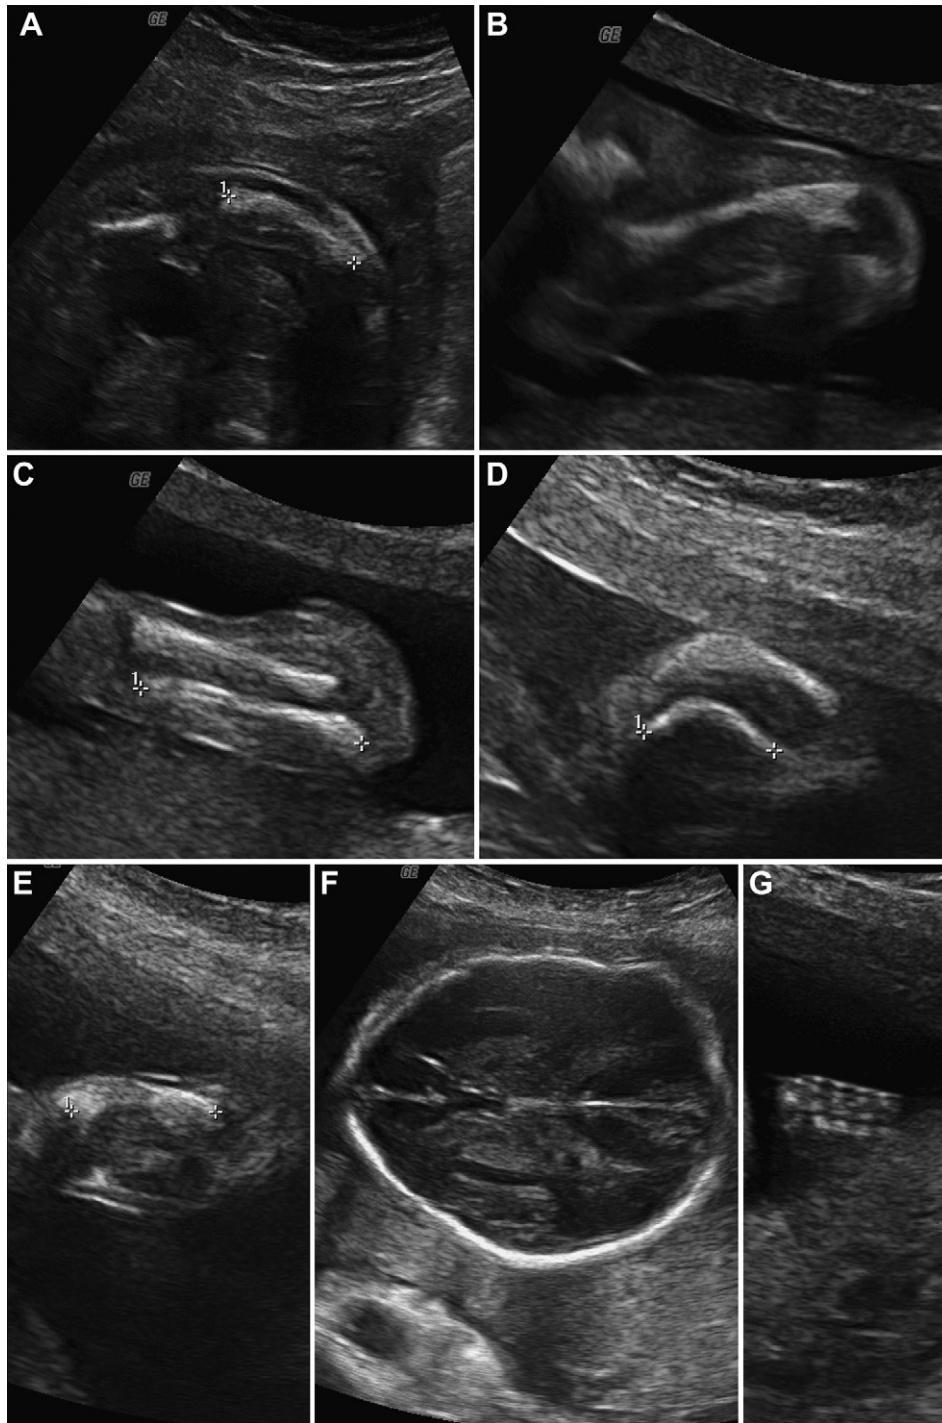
Prenatal ultrasound at 24 weeks of gestation shows (A) curved femur, (B) humerus with thin cortex and shafts and fracture, (C) radius and ulna with hypomineralization, (D) curved tibia and fibula, (E) curved femur, (F) hypomineralization of the skull with too-well-seen brain structure, and (G) a normal hand with five fingers.
